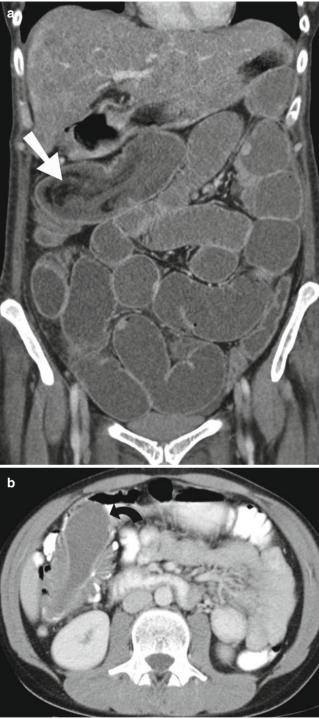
Intussusception. (a) Coronal CT scan reformation demonstrates colocolonic intussusception in the hepatic flexure of the colon. The intussusceptum (*straight arrow*) is causing high-grade bowel obstruction. (b) Axial contrast-enhanced CT demonstrates colocolonic intussusception due to a duplication cyst (*curved arrow*)
